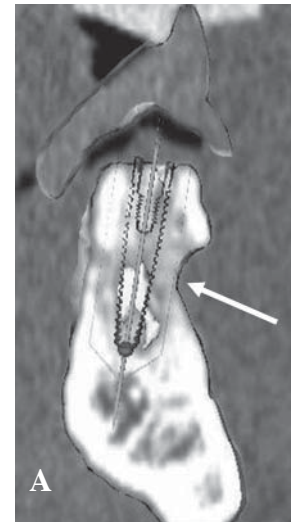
Treatment of patient in Figure 23. A. (above) Cross-sectional image (NobelProcera®) of planning of implant placement. Note the differences in buccal-lingual contour and density of the distracted bone, B. (facing page) 3-D reformation of alveolar distraction area with implants virtually placed, C. Nobel-Guide™ in place with implants inserted, D. Periapical radiograph after alveolar distraction, implant placement, and restoration. Note the normal pattern of bone surrounding implants, E. Final restoration in place.
